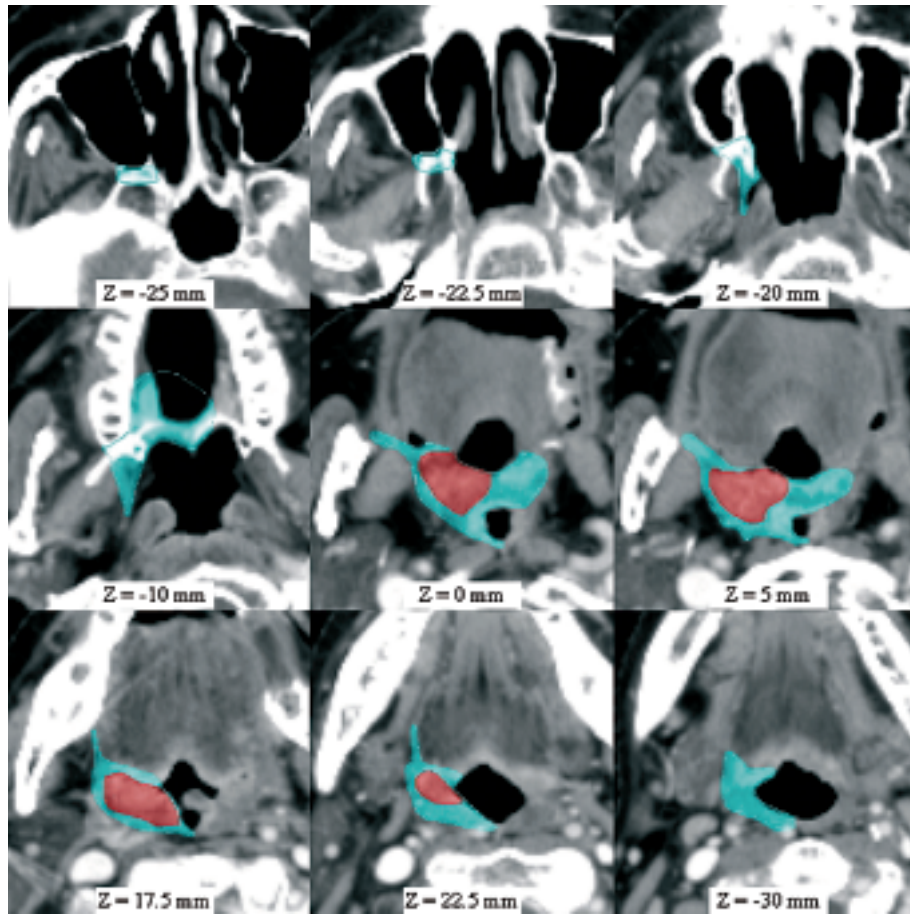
Axial CT slices of a 48y female with a T2 tumor of the right tonsilla (GTV in red) extending upwards on the soft palate through the posterior pillar. The CTV (in light blue) includes the pterygopalatine fossa (slices $z = -10$ to -25 mm), the soft palate and the mucosa of the hard palate (not directly visualized because of partial volume effect, CTV had to be artificially extended into the air on slice $z = -10$ mm to compensate for this absence of visualization); the glossotonsillar sulcus and the constrictor muscles of the posterior pharyngeal wall.
